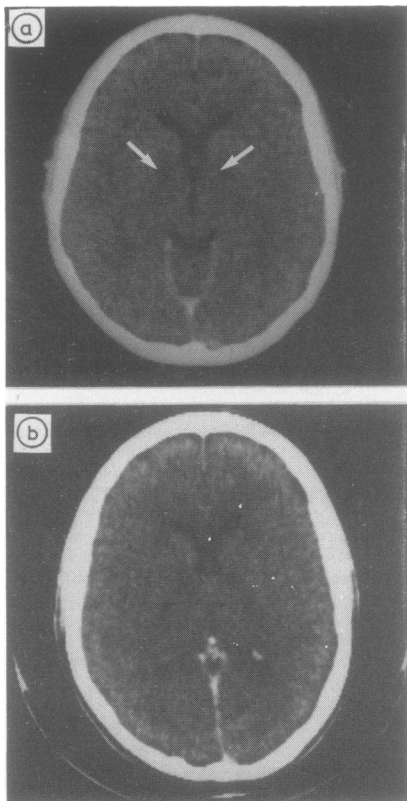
Fig CT scans with contrast enhancement: (a) 26 days (b) 13 months after acute carbon monoxide poisoning. Arrow indicates bilateral areas of low-density in the globus pallidus.
